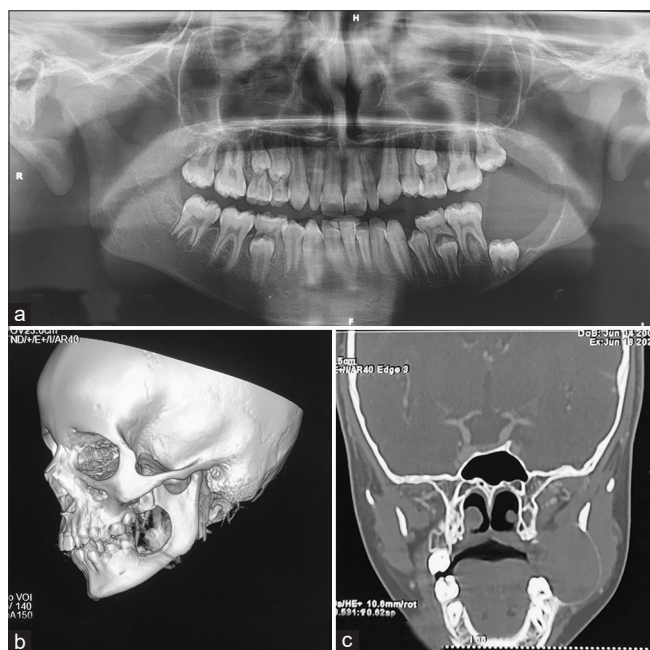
Orthopantomograph (OPG) and Computerised Tomographic Images (CT Images) showing the extent of the osteolytic lesion along with significant expansion and cortical perforation. (Case-1) (a-c)
